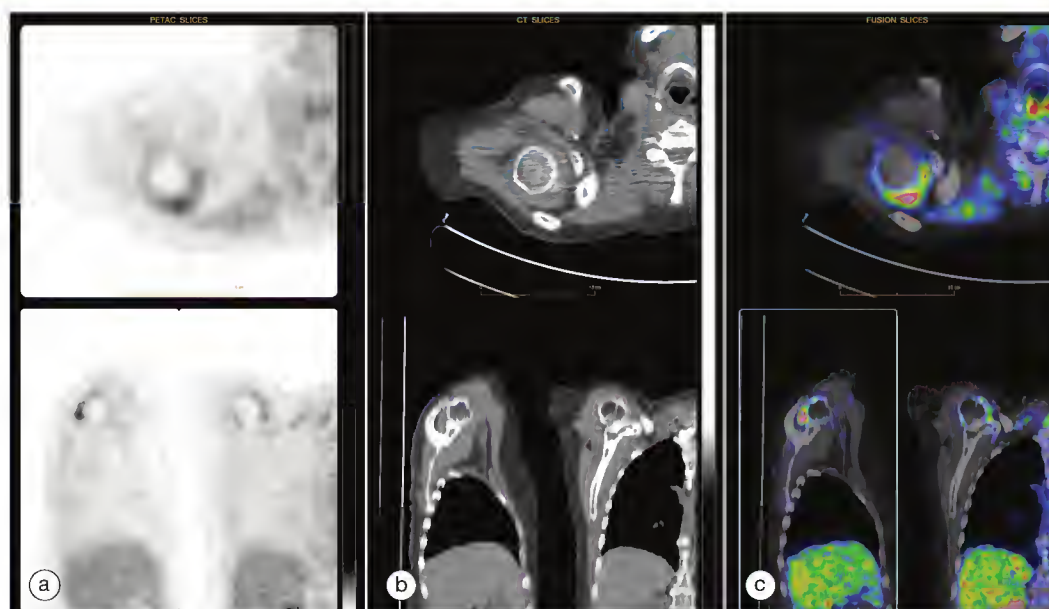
^{18}F -fluorodeoxyglucose positron emission tomographic (^{18}F -FDG-PET) images (a), computed tomographic (CT) images (b), and fused PET/CT images (c) of a patient referred for oncologic reasons. Uptake in the right shoulder is incidentally highlighted.
